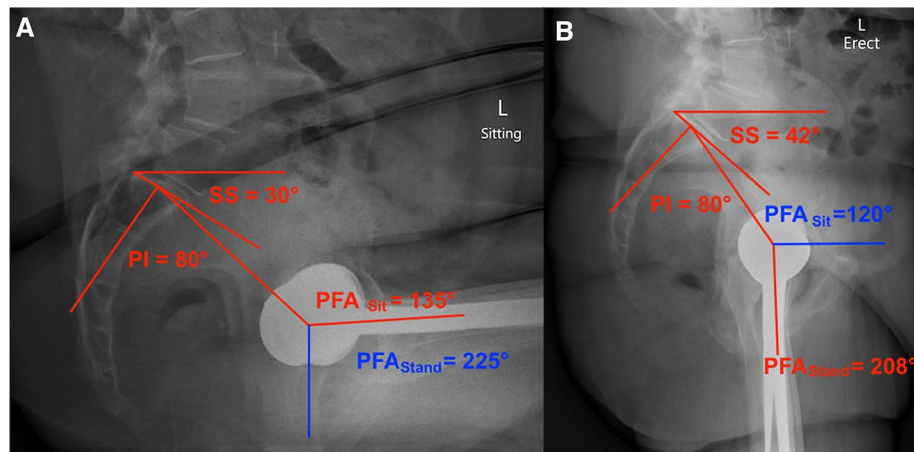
Lateral X-rays of a patient in sitting and standing positions depicting the biomechanical changes in pelvifemoral angle (PFA) and sacral slope (SS) from a sitting (Image A) to standing (Image B) position. With a mobile spino-pelvic complex, from sitting to standing the SS increases from 30° to 42°, which represents an increased anterior pelvic tilt. The actual PFA is represented in red text, while the apparent PFA is in blue text. From Image A, a stuck-sitting phenomenon occurs when the SS remains at a low value (30°), even when changing from a sitting (red) to standing (blue) position. As such, compensatory femoral motion may result in a larger PFA (225°
